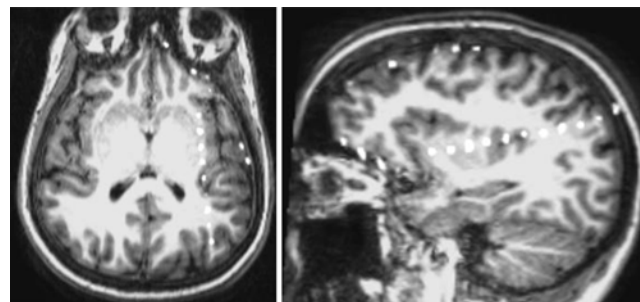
Coronal (left) and sagittal (right) CT-MRI reconstructions demonstrating the posterior oblique trajectory for insular depth electrode placement.
